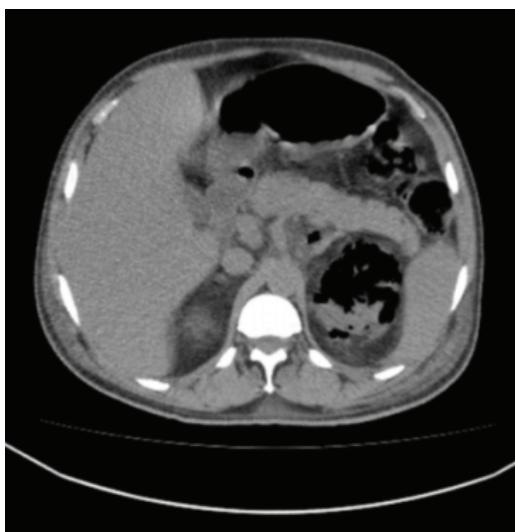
CT abdomen showing multiple air pockets in the renal parenchyma, perinephric and anterior paranephric spaces.
